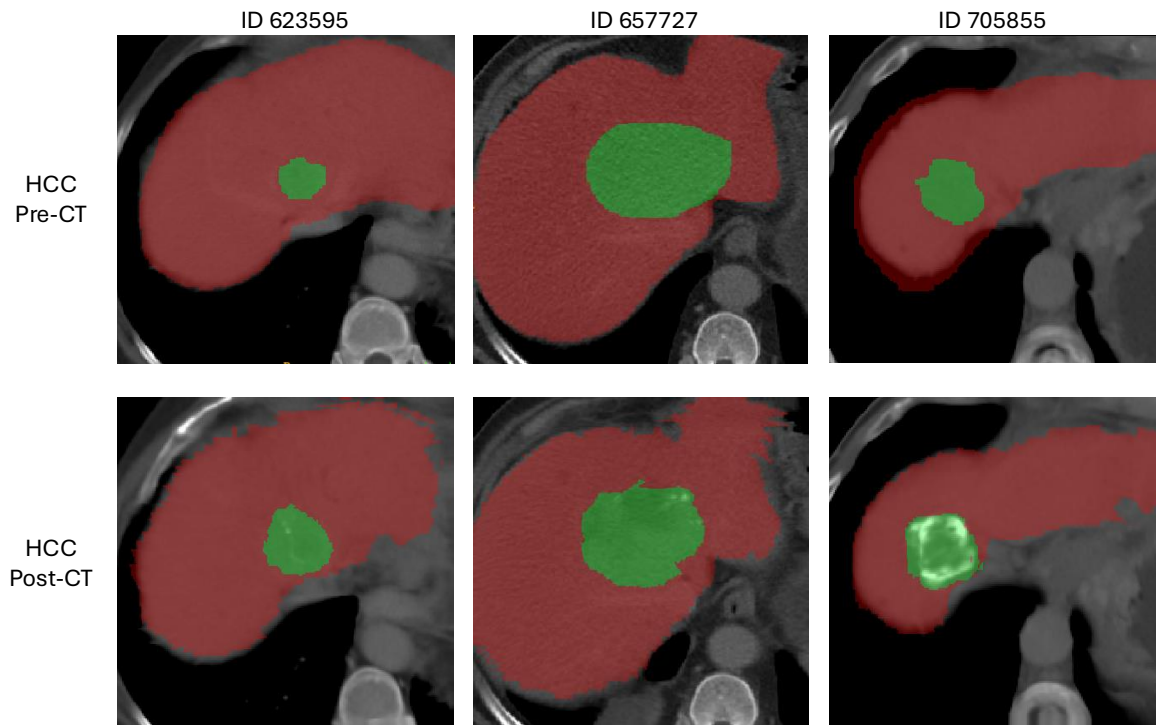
Example of HCC-TACE dataset. The first row shows HCC Pre-CT images, and the second row shows HCC Post-CT images. The red mask represents the liver, while the green mask represents the HCC tumor. In post-treatment CT imaging of HCC, particularly after Transarterial Chemoembolization (TACE), the viable tumor region and its enhancement intensity decrease due to Lipiodol accumulation and treatment-induced necrosis. Lipiodol appears hyperdense (bright) on post-treatment CT, indicating areas that have been successfully embolized.
